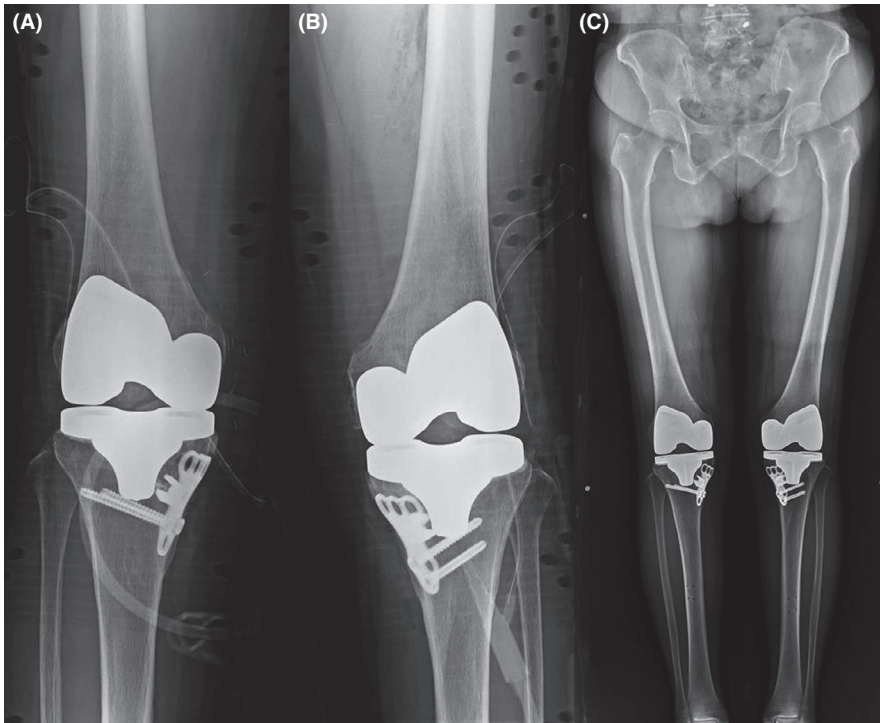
(A and B) A 69-year-old woman underwent bilateral robot-assisted total TKA after removal of proximal screws that interfered with tibial component fixation. (C) A 4-week postoperative standing AP radiograph shows a right HKA angle of 0.2° and a left HKA angle of -1.9°
